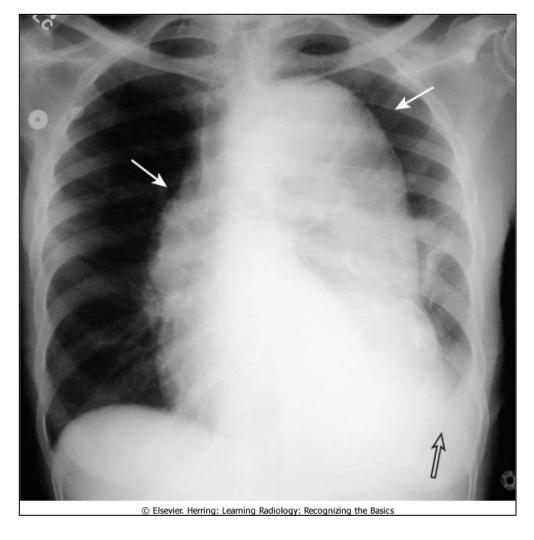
Aortic dissection. Conventional radiographs are not sensitive enough to be diagnostically reliable for aortic dissection, but they may point to the diagnosis when several imaging findings occur together, especially in the proper clinical setting. "Widening of the mediastinum" is frequently not present and is a poor means of establishing the diagnosis, although in this patient the mediastinum is clearly widened by an enlarged aorta (closed white arrows). Also, a left pleural effusion is present (open black arrow). The combination of a widened mediastinum and a left pleural effusion in a patient with chest pain should alert you to the possibility of an aortic dissection.
